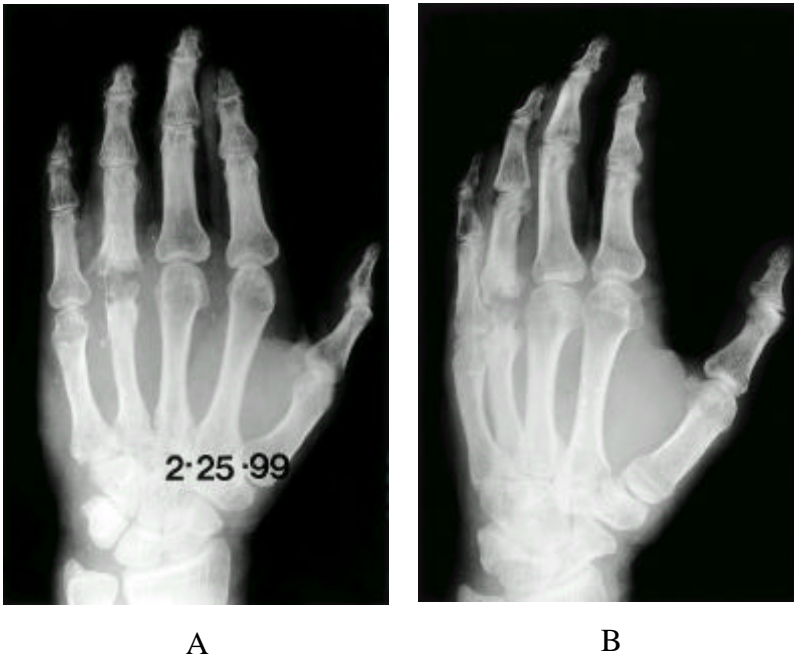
A, B. Radiographs of 9 months postoperatively show that bony union of metacarpal bone and phalanx with the grafted bone.
